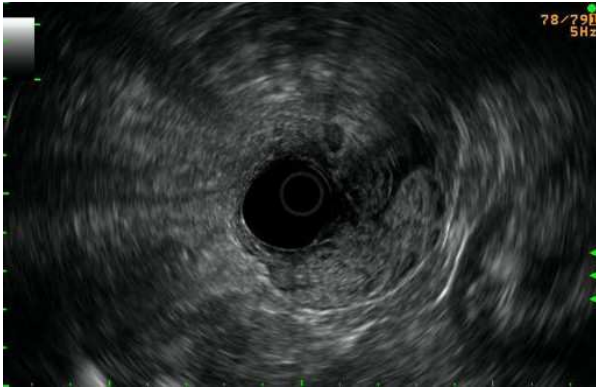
Endoscopic ultrasonography revealing the depth of invasion of the tumor into the muscular layers. The serosa was respected.
